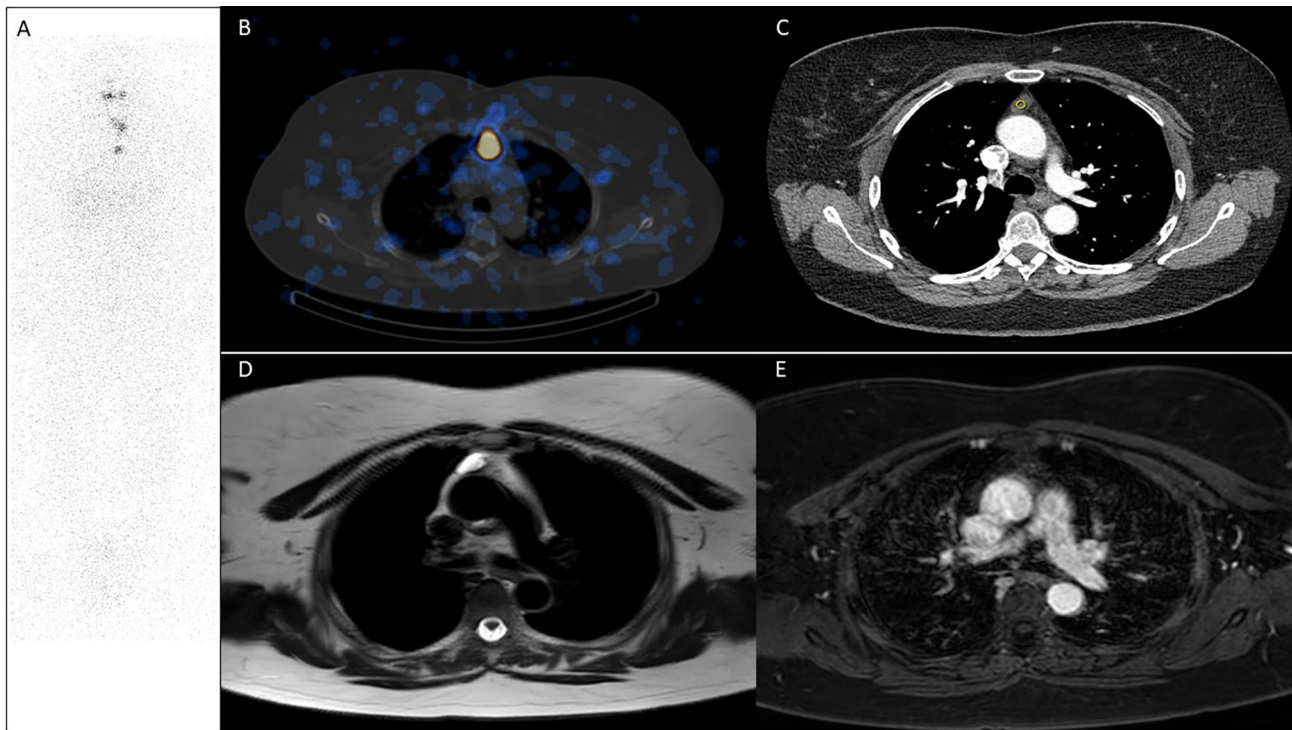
I-131 retention in thymic cyst. a RAI-WBS, b SPECT/CT, c CT with contrast, d MRI T2-weighted, e MRI post-gadolinium identified I-131 retention in thymic cyst
